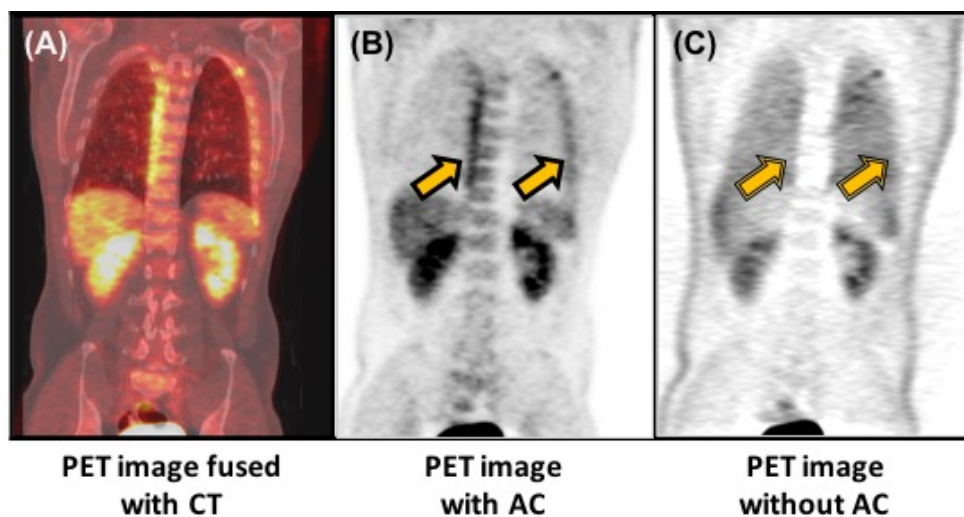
Artifacts when a patient shifted between CT and PET scans
